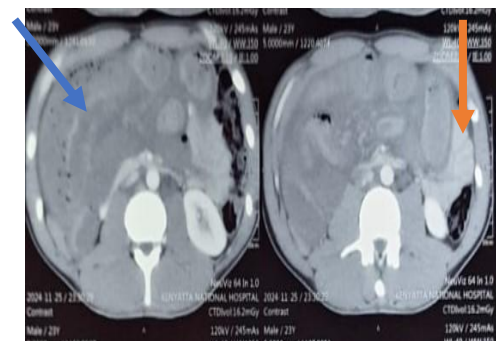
preoperative axial view of abdominal CT scan image of patient. Blue arrow shows multiple pneumatosis intestinalis and orange arrow shows one of the multiple dilated bowel loops.
